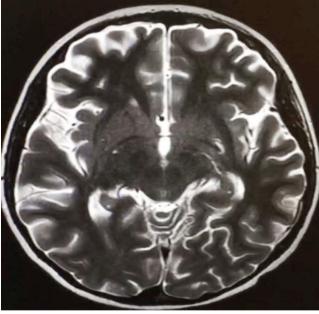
MRI after 3 weeks
